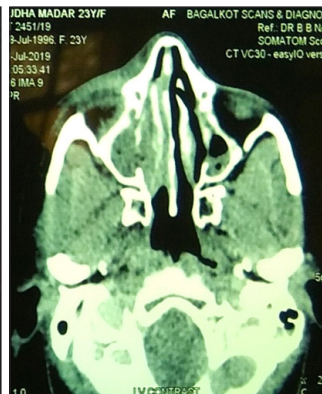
CT Nose and PNS (axial section)
